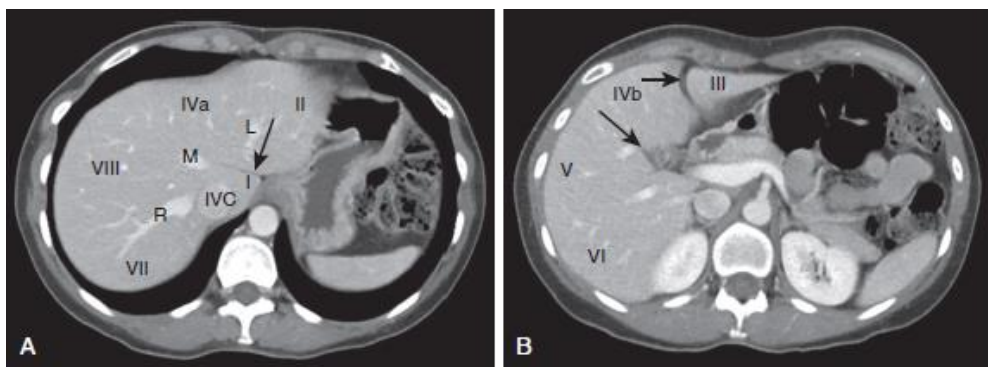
Normal segmental anatomy of liver on CT. A, Axial contrast-enhanced CT image through liver above plane of portal vein shows right (R), middle (M), and left (L) hepatic veins between hepatic segments that drain to inferior vena cava (IVC). Note fissure for ligamentum venosum (arrow) anterior to caudate lobe (I), as well as lateral (II), medial (IVa), anterior (VIII), and posterior (VII) segments. B, Axial contrast-enhanced CT image through liver below plane of portal vein shows left intersegmental fissure (short arrow) and interlobar fissure (long arrow), as well as lateral (III), medial (IVb), anterior (V), and posterior (VI) segments. (Siegelman, 2010).
